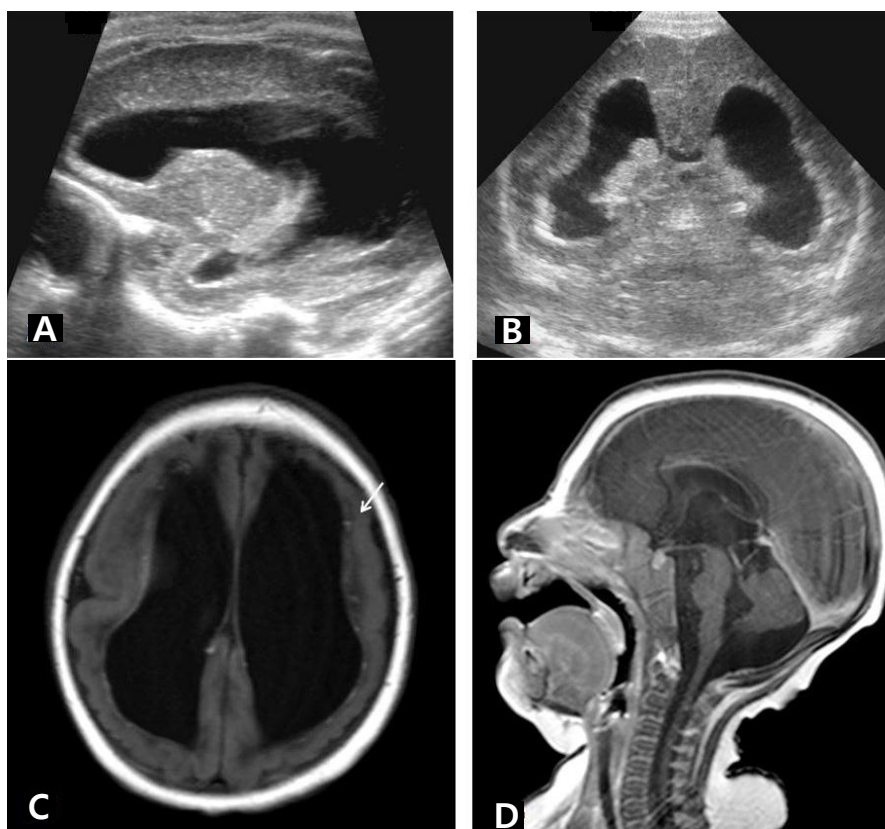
(A, B) Brain ultrasonography performed 2 days after birth shows ventriculomegaly with increased periventricular echogenicity. (C, D) Brain magnetic resonance imaging at postnatal age 4 months shows cortical malformation and extensive white matter volume loss with circumventricular calcifications (arrow) and cerebellar hypoplasia.
